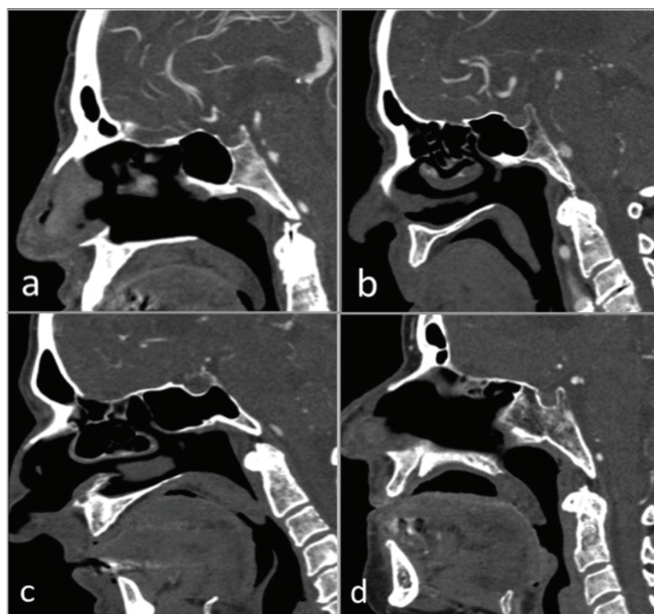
Degree of pneumatization. Sagittal computed tomography angiography images demonstrate presellar (a), sellar (b), postsellar (c) and conchal (d) pneumatization patterns of the sphenoid sinus.
